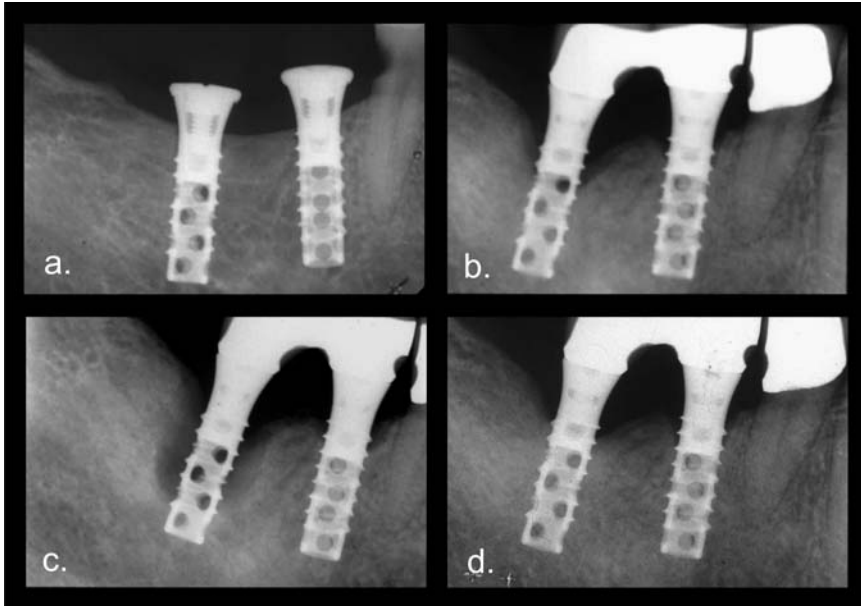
Patient KR, a 45-year-old man. (a) The missing lower-right molars were replaced with 2 hollow-screw implants. (b) After 3 years, a bony defect developed around the most posterior implant. (c) Conservative measures (ultrasonic curettage and chlorhexidine irrigation) failed to arrest the lesion's development, which, in 3 months, progressed to the state as shown. At that time, an open-flap debridement and disinfection was performed. (d) Eventually, the lesion healed to about 80% of the original bone level.
